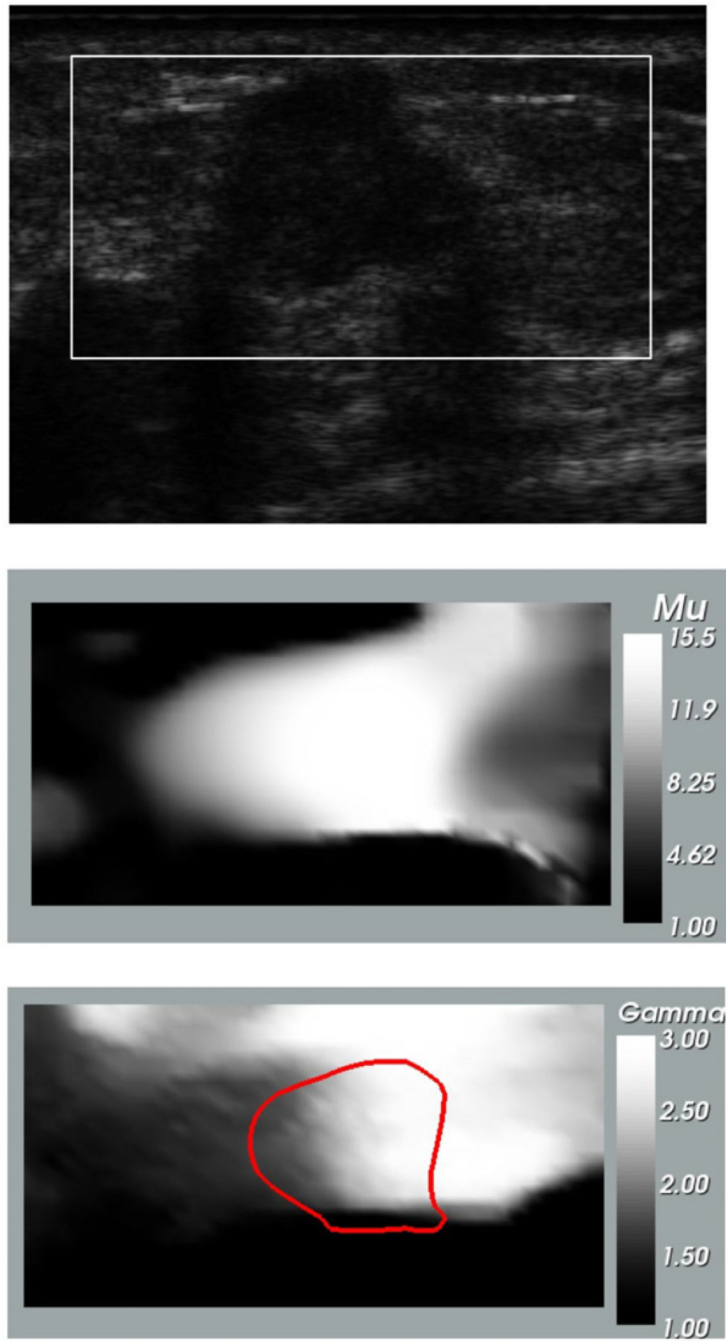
Images for infiltrating ductal carcinoma. Top: B-mode ultrasound image at small strain; middle: relative shear modulus at zero strain (μ_0); bottom: nonlinear parameter (γ). The dark curve represents the iso-contour of $\mu = 13$ and is plotted to locate the tumor in the nonlinear parameter image.
